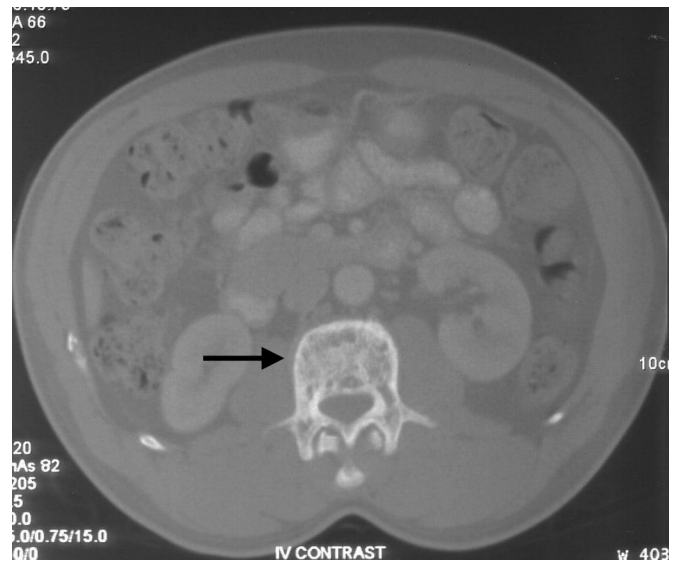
Axial image from the computed tomography scan of the abdomen showed coarse and widely separated trabeculae and cortical thickening, suggestive of Paget's disease in the L2 vertebral body (black arrow).
